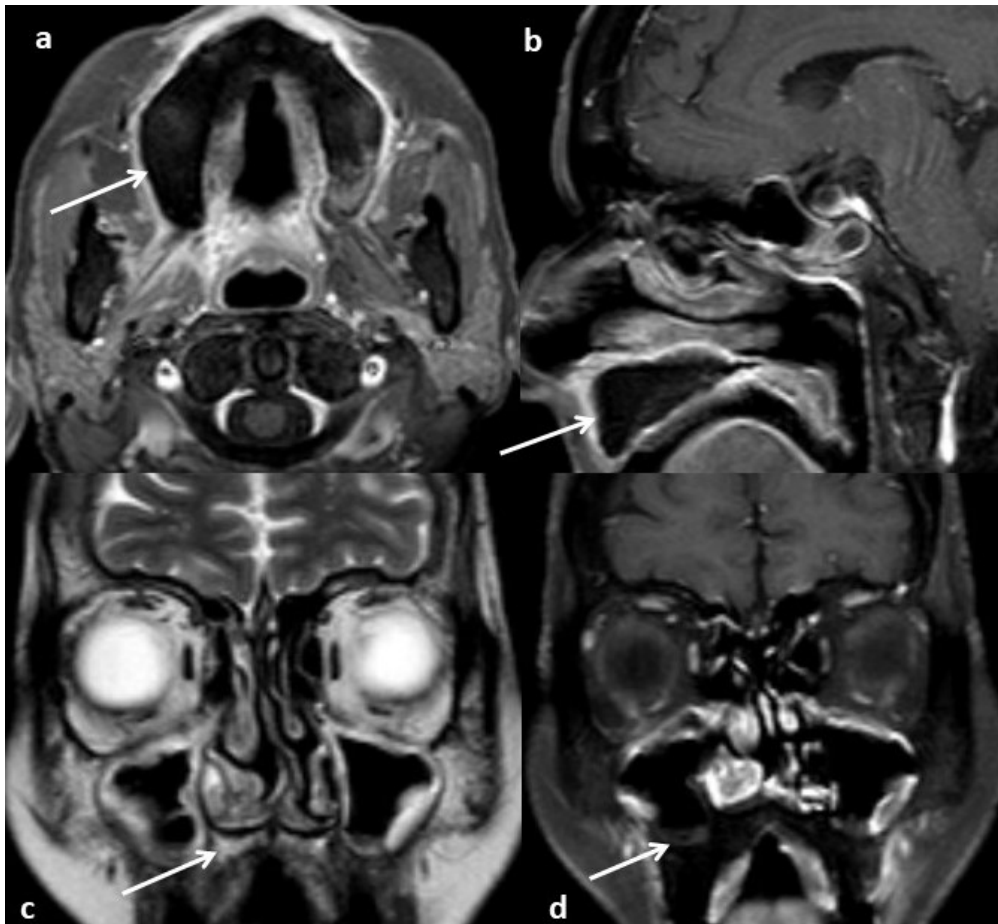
(a) Axial contrast-enhanced MRI (b) Sagittal contrast-enhanced MRI (c) Coronal T2-weighted MRI and (d) Coronal contrast-enhanced MRI show expansion and nonenhancement of the alveolar process of the maxilla (predominantly on the right side) and the hard palate with peripheral soft tissue enhancement (arrows).
